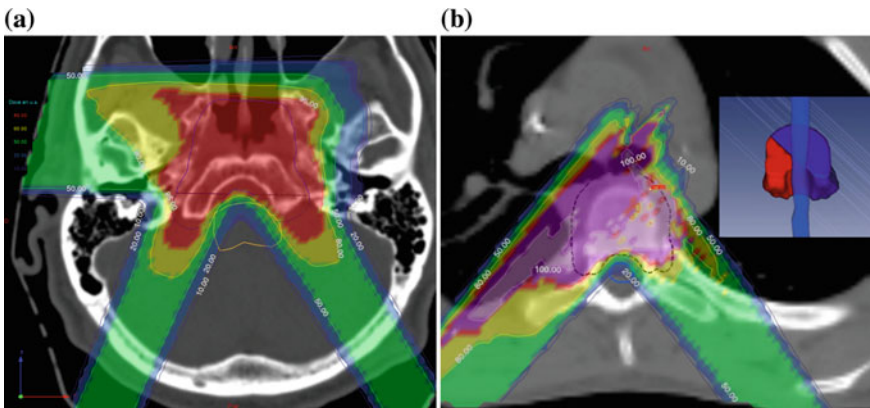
Axial CT images with dose display in percent for typical chordoma cases, with a combination of patch/through fields: a three fields which irradiate anterior and posterior portions of the target while avoiding brainstem, b two fields avoiding spinal cord
